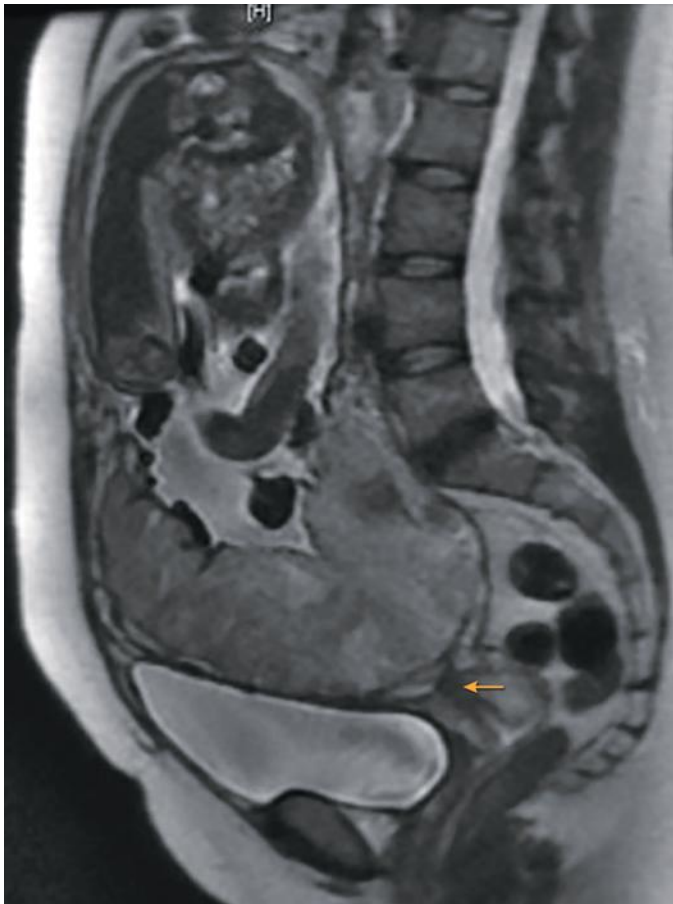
Central placenta previa at 34 weeks' gestation, history of one prior cesarean delivery. Sagittal T2-weighted imaging demonstrates a central placenta previa covering the internal os of the cervix (*arrow*). The placenta is homogeneous in signal intensity, normal in thickness, with an intact myometrial margin.
